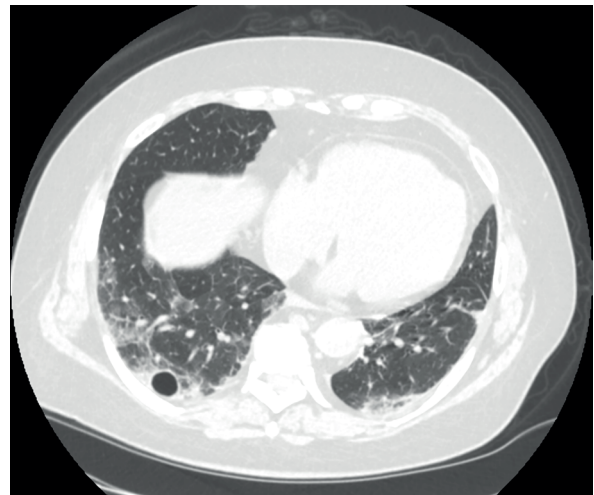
HRCT images of a 63 y.o. old woman at day 15 of Covid-19 pneumonia. Note multiple diffuse consolidations with GGOs, reticular and crazy paving pattern, together with subpleural bands and small lung cavitations.
